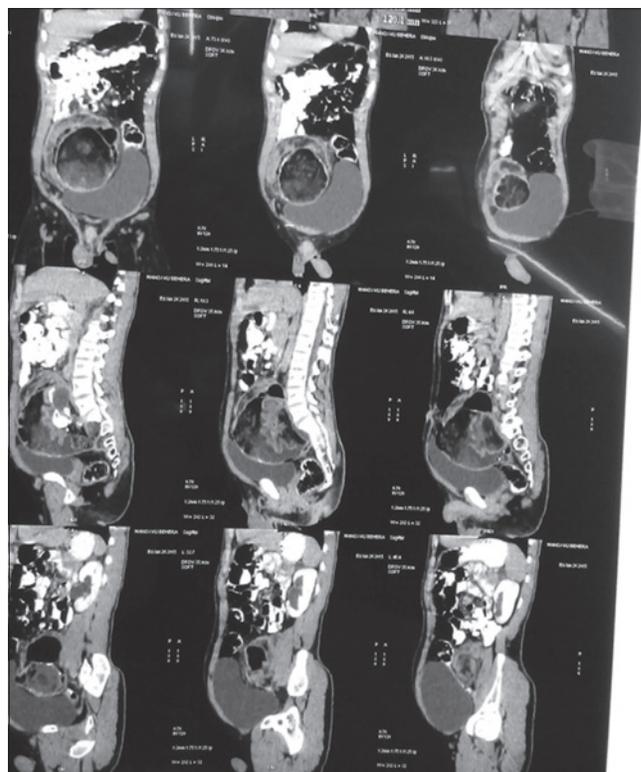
Coronal and sagittal images of contrast-enhanced computed tomography abdomen and pelvis showing heterogeneous well-defined lesion in the pelvis superior to urinary bladder
